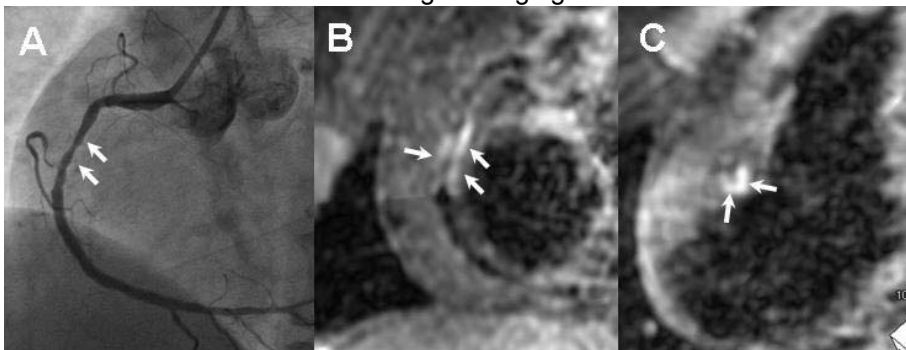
X-ray coronary angiogram and T1 weighted whole heart coronary plaque MRI in a patient with CAD. X-ray angiogram (A) revealed significant stenosis in RCA (arrows). Hyperintense coronary plaque was clearly revealed on sliding thin SLAB MIP images reconstructed along RCA (B) and perpendicular to RCA (C).
